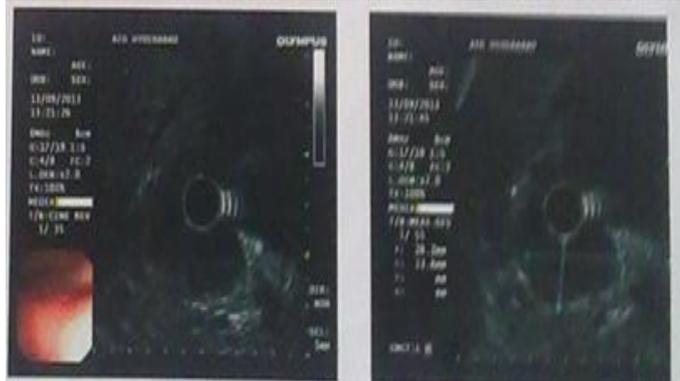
Endoscopic Ultrasound
